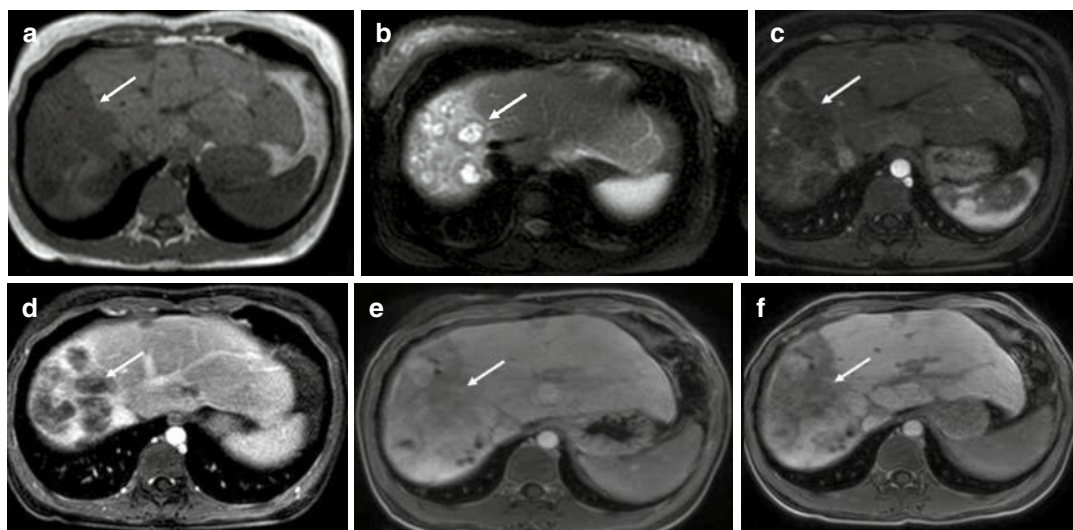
A 26-year-old female with hepatic epithelioid hemangioendothelioma. (a) Axial T1-weighted MRI showed a geographic area of hypointensity in the right lobe of the liver (arrow). (b) Axial T2-weighted MRI showed multiple hyperintense lesions with a hypointense rim in the periphery of the right lobe of the liver (arrow). (c–e) Axial
